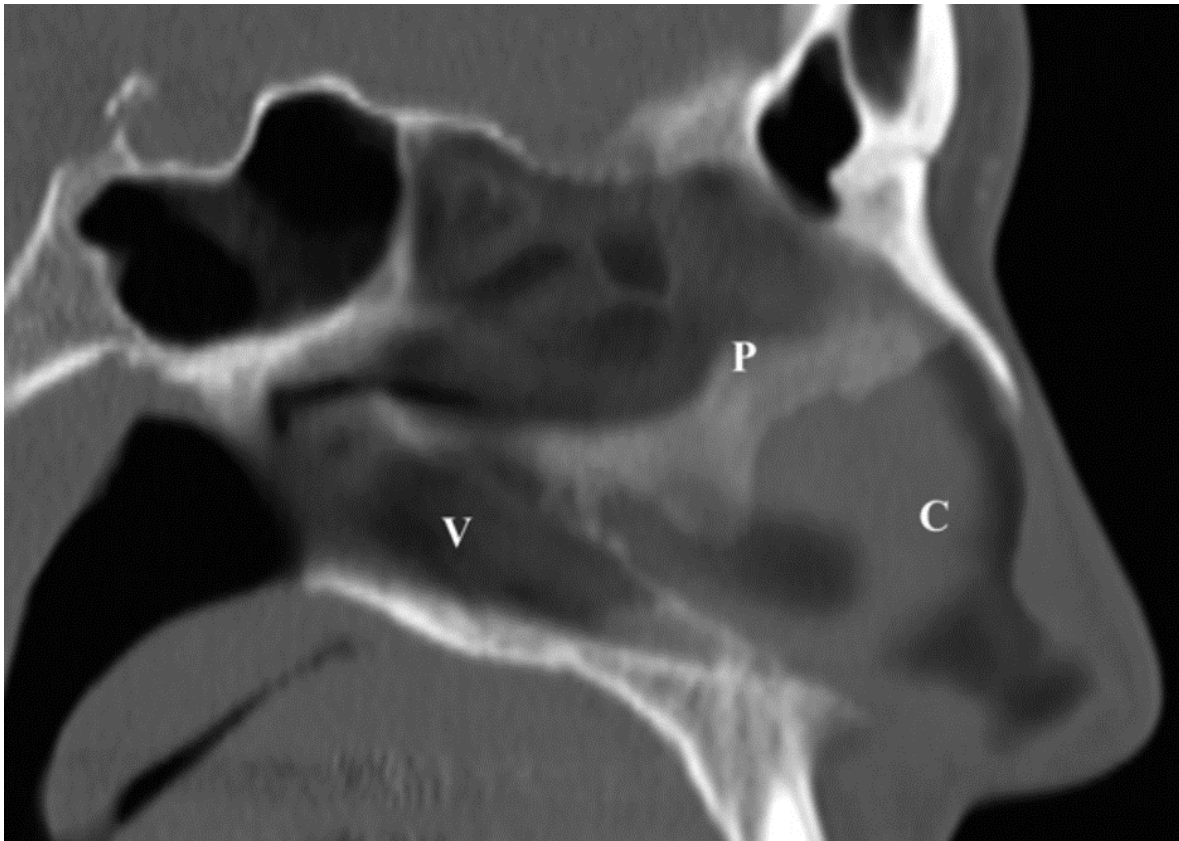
Sagittal view of MRI showing the total septal area (Kim et al, 2008).*
